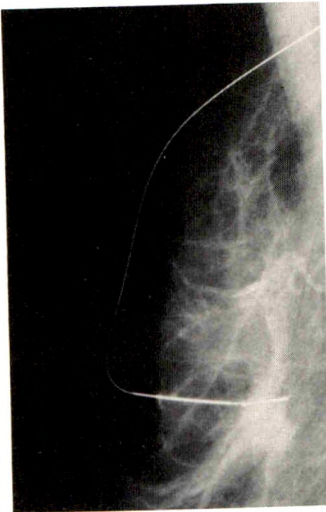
After sonographically guided localization, a mammogram should be obtained to confirm relationship of lesion to wire.
